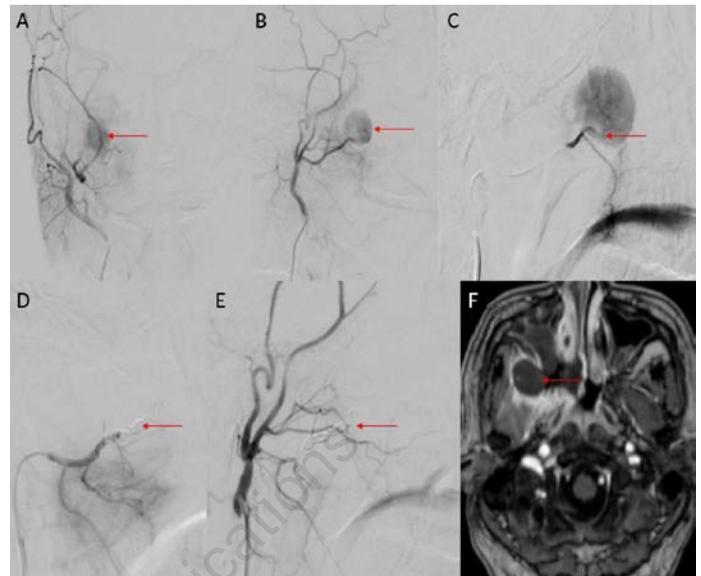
Internal maxillary artery pseudoaneurysm. (A) and (B) Right external carotid artery angiogram both antero-posterior and lateral images show a pseudoaneurysm arising from the internal maxillary artery. (C) Selective microcatheter angiogram shows the aneurysm better. (D) Coil embolization of the internal maxillary artery is done near the aneurysm. (E) Post coil embolization angiogram shows non-opacification of the aneurysm. (F) Follow-up magnetic resonance imaging post contrast axial image shows non-opacification of the pseudoaneurysm.
